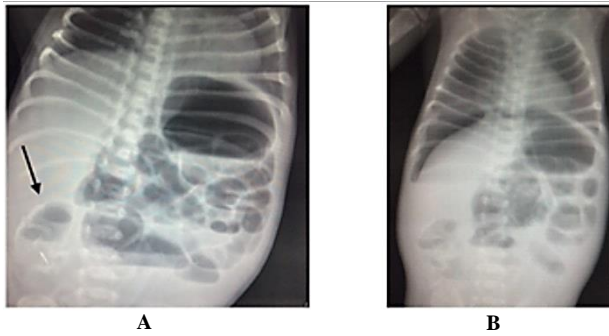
A) X-ray abdomen AP supine view showing multiple air fluid levels and a cystic calcified lesion in the right iliac fossa (arrow) suggestive of a meconium pseudocyst. B) X-ray abdomen erect view of the same baby showing air under diaphragm.
